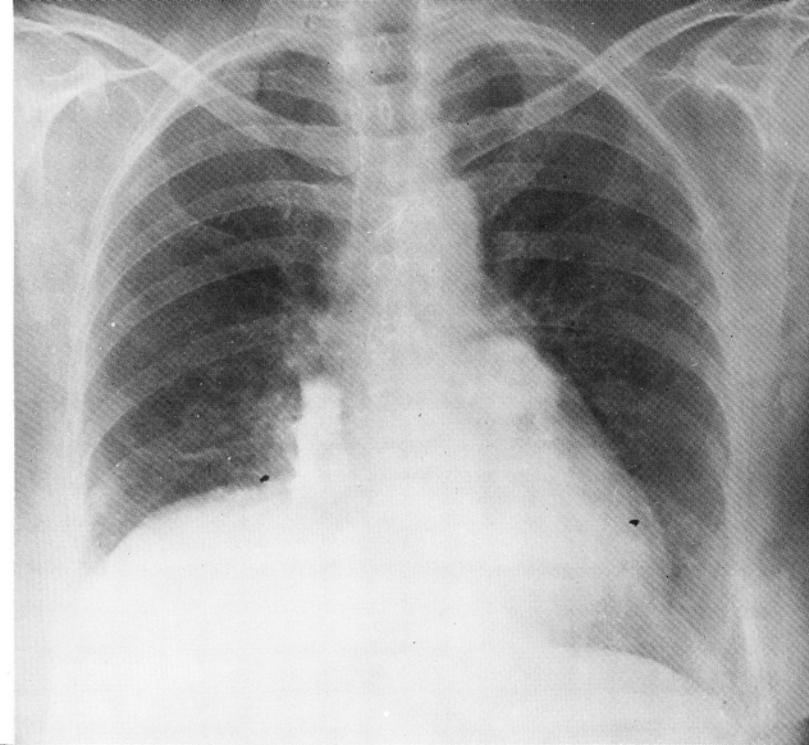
Frontal roentgenogram, in September, 1962 showing calcified foci of recurrence.
